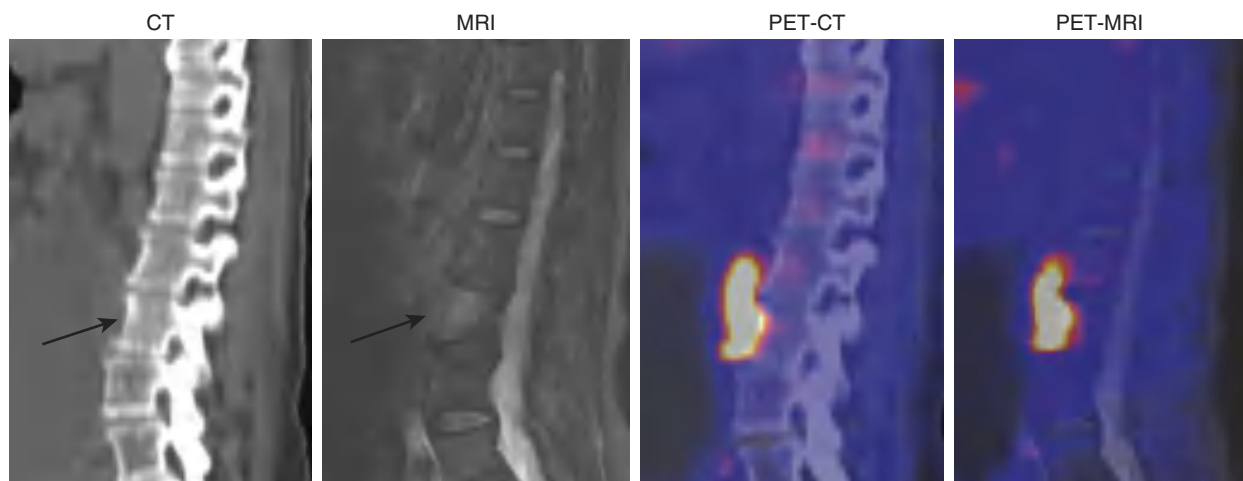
Neuroblastoma PET/CT sagittal fused image demonstrated partial mis-registration of avid disease, occult on the low-dose noncontrast CT. PET/MRI sagittal fused image demonstrated correct image co-registration with corresponding T2-weighted hyperintensity in L3 vertebra, confirming L3 marrow involvement, delineated on the MR and not on the CT (arrow). (From Sepehrizadeh T, Jong I, DeVeer M, Malhotra A. PET/MRI in paediatric disease. *Eur J Radiol*. 2021;144:109987. Fig. 2.)
